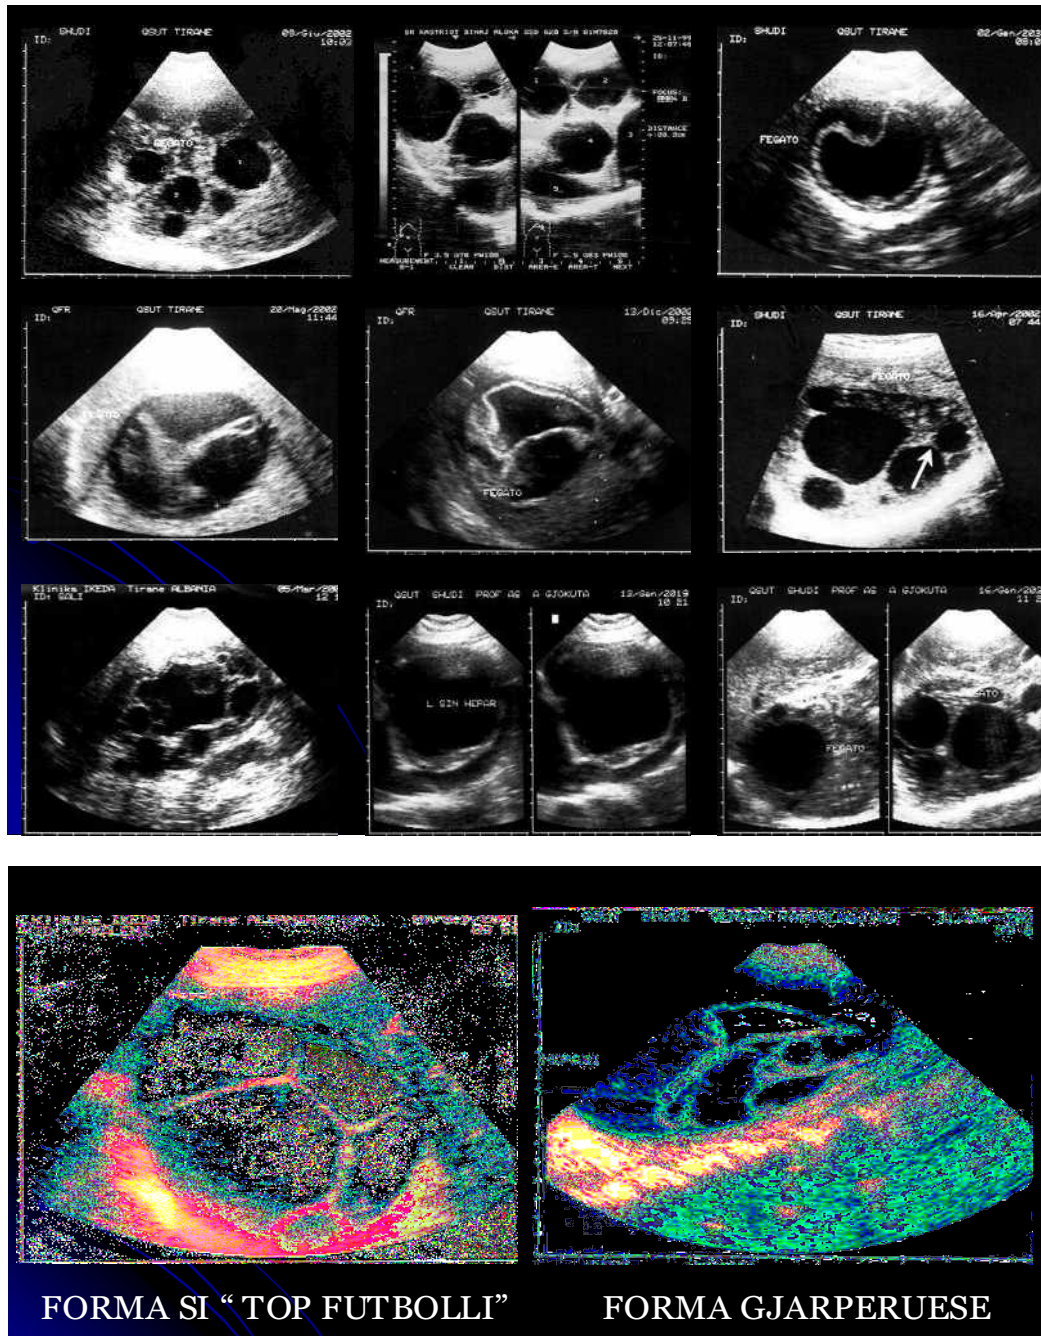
Ultrasound images of *Echinococcus granulosus*
